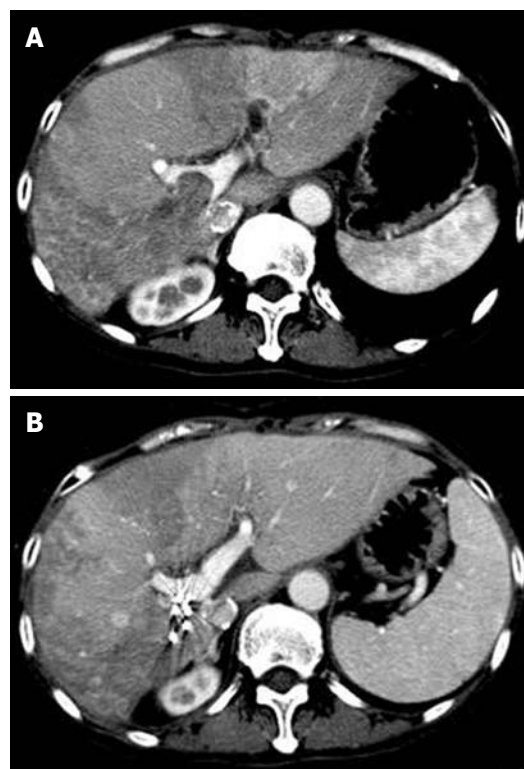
Enhanced computed tomography shows thrombus before ¹²⁵I seed implantation (A) and absence of tumor thrombi 4 mo after ¹²⁵I seed implantation (B).
